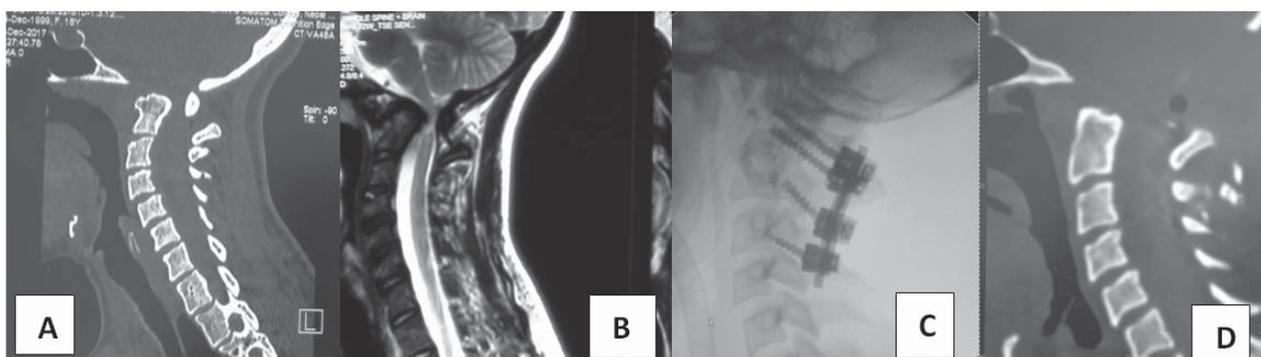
Pre operative (pre op) and post operative (post op) images of congenital atlantoaxial subluxation. A pre op CT scan and B pre op MRI showing AAS and compression of cervicomedullary junction, C post op cervical x ray with posterior fixation and fusion, D Post op CT scan showing adequate decompression.
